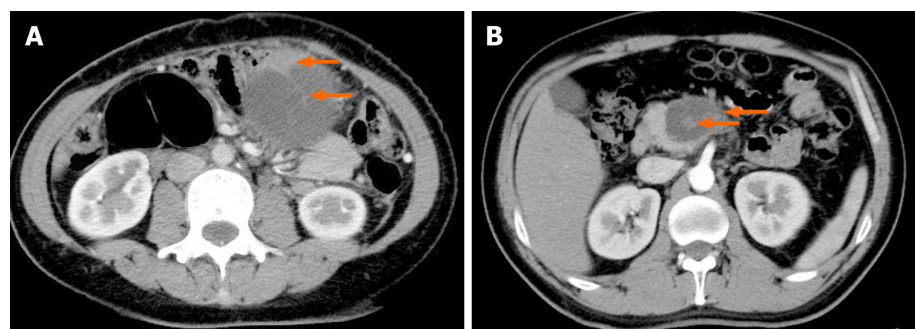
Retrospective observation of computed tomography images. A: Radiological signs of nonliquid contents and some cord-like shadows (arrow) in the female; B: Solid debris (arrow) in the male.
